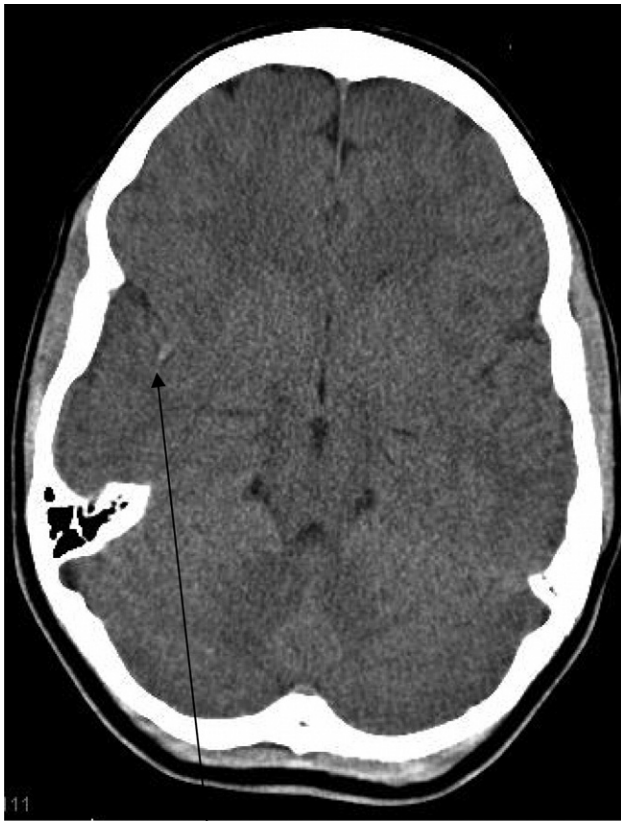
Computed tomography of the head demonstrates hyperdensity in the right middle cerebral artery region (arrow).
